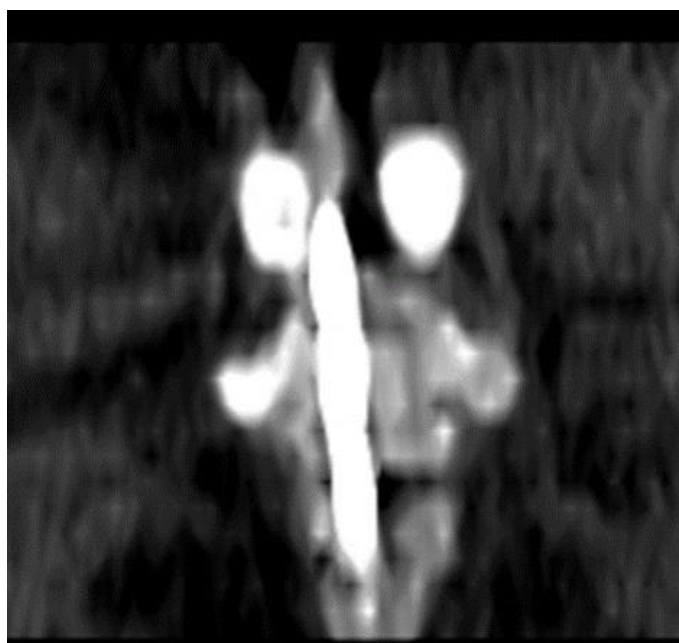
CT control: coccygeoplasty was performed with one needle along the midline, from the level of S4, passing through the coccyx.*
